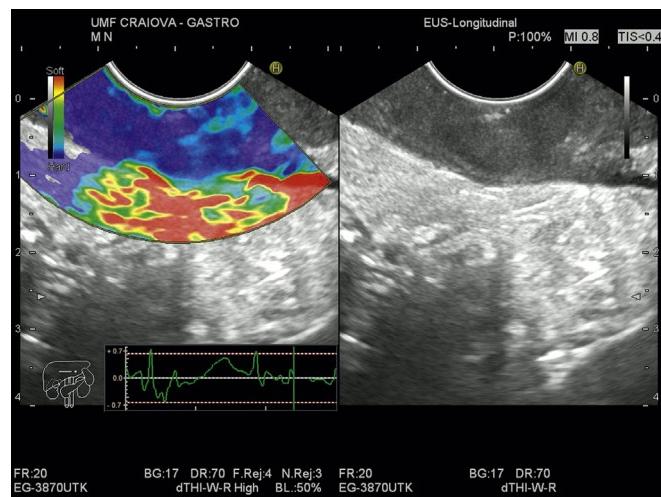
Pancreatic adenocarcinoma. Endoscopic ultrasound elastography with EUS-guided FNA, showing the same appearance of a relatively homogeneous hard (blue) focal pancreatic mass as compared to the surrounding tissues (left).
